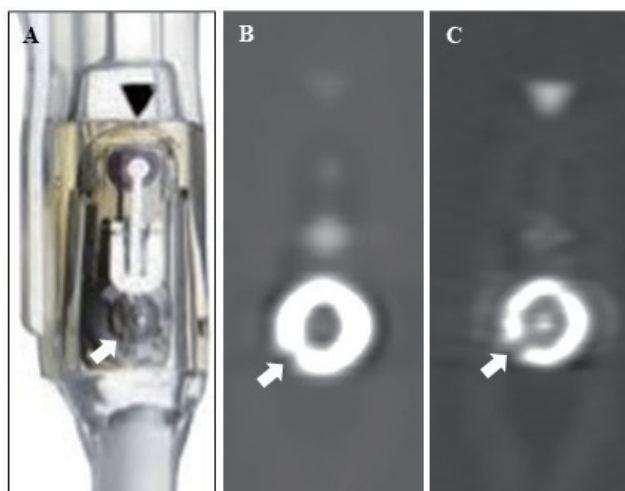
Visualization of the ventriculoperitoneal shunt valve pressure adjustment system (A) by means of the photon-counting detector computed tomography in a single-acquisition high-resolution mode with the iterative metal artifact reduction and utilization of the convolution kernel Hr 56 for attainment of reconstructed images with the slice thickness of 0.4 mm (B) and 0.2 mm (C). The latter provided excellent visualization of the cam position indicator (arrow).
